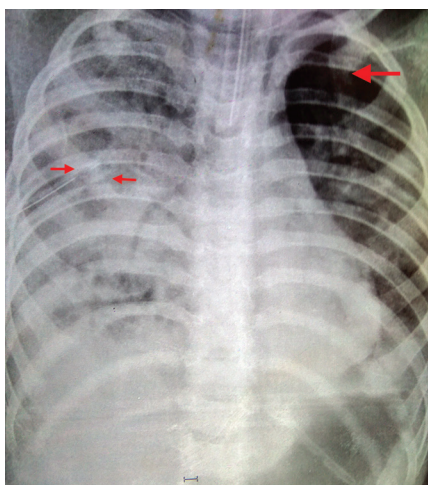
Chest X-ray of the patient after intercostal chest tube drainage. Red arrow showing intercostal drainage tube on right side. The whole lung shows heterogeneous opacity. Air also seen in left pleura (red arrow)
